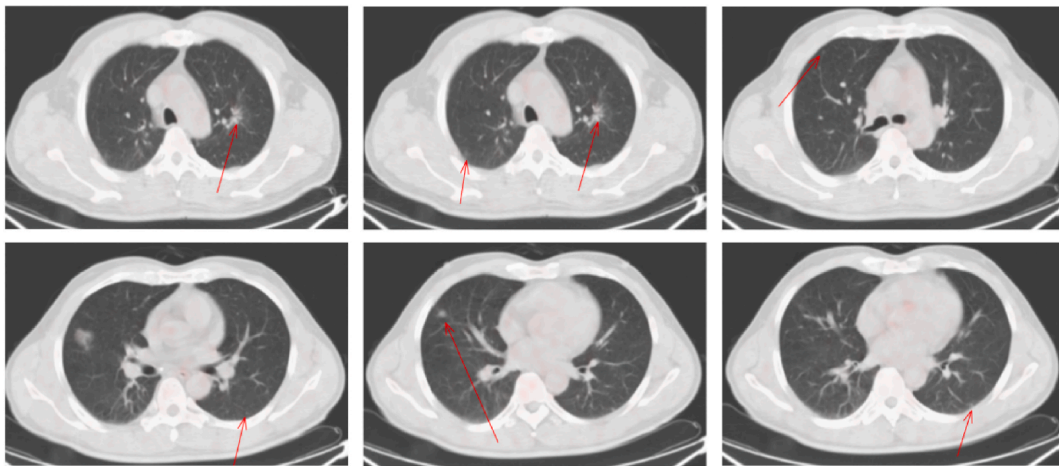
PET CT shows multiple pulmonary nodules.
